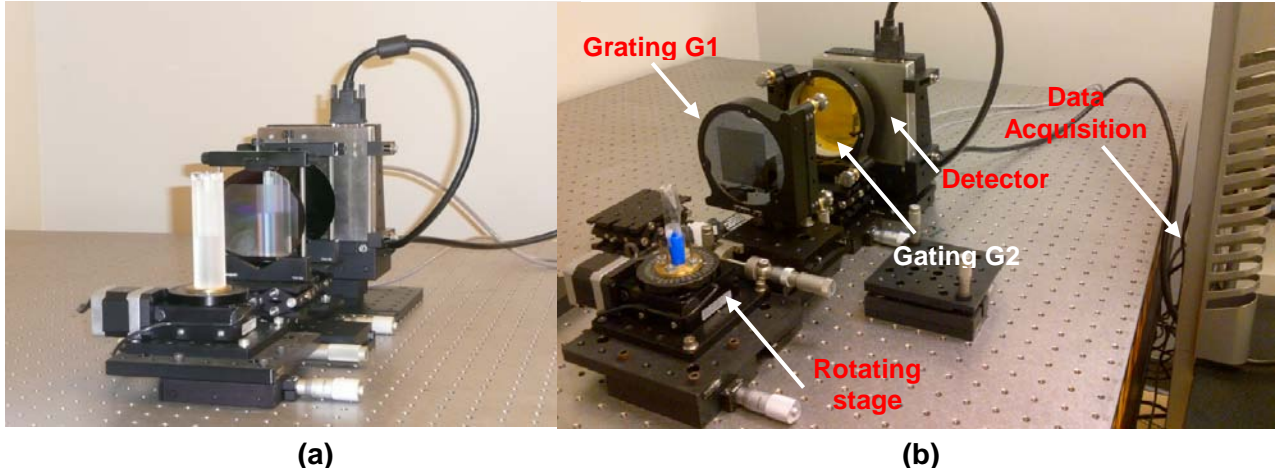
Pictures showing the prototype x-ray phase contrast CT: (a) configuration of the initial x-ray phase contrast CT system and (b) the prototype system with performance initially optimized.
